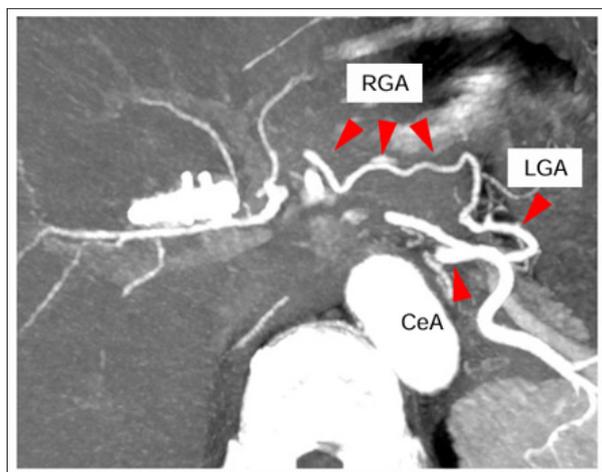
Postoperative Dynamic Computed Tomography CT showed RGA had more enlarged than preoperative. RGA right gastric artery; LGA left gastric artery; CeA celiac axis.
